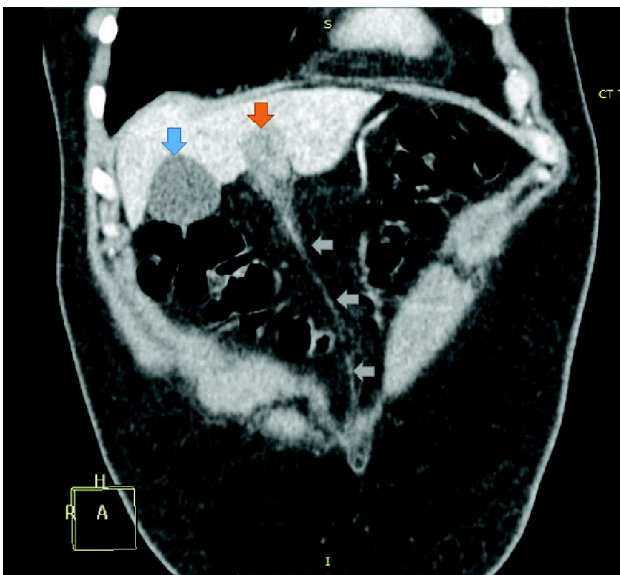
Contrast enhanced CT scan (portovenous phase, coronal view) showing ill-defined hypodense mass in the region of falciform ligament which itself is markedly thickened (red arrow), note the thickened umbilical vein remnant (green arrows) and normal gall bladder (blue arrow).
